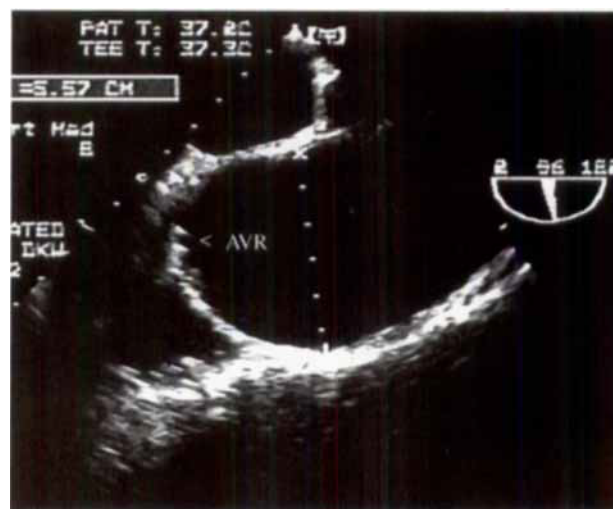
Transesophageal echocardiogram in Case No. 2: Longitudinal plan, showing marked dilation of ascending aorta. Prosthetic aortic valve (AVR) is at left.
